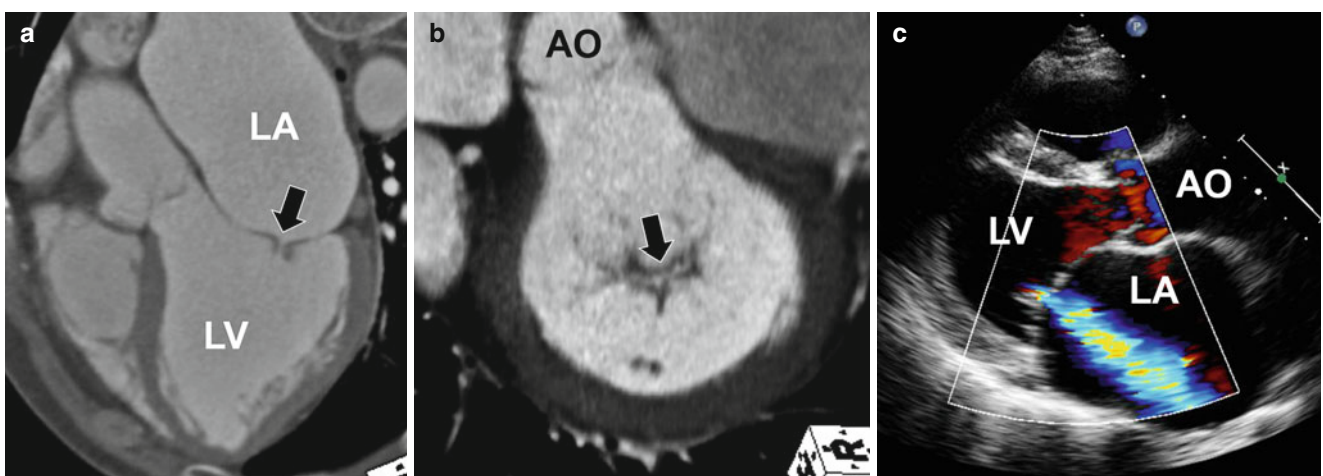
Functional mitral regurgitation due to mitral annular dilatation. (a) Three-chamber view of CT image demonstrates central coaptation defect (*arrow*) in the mitral valve due to annular dilatation. The left ventricle (*LV*) is dilated and shows idiopathic systolic dysfunction
